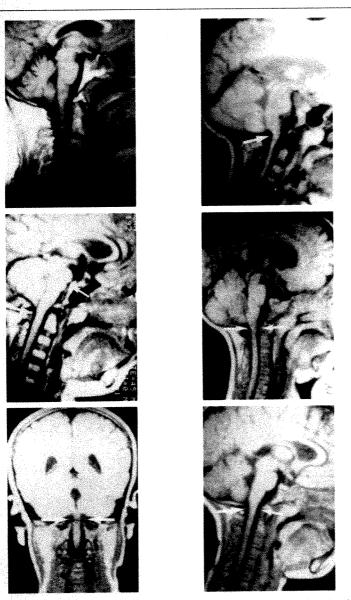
Magnetic resonance imaging appearance in patients with achondroplasia. Top left, Normal. Top right, Posterior compression of medulla. Center left, Anterior indentation of pons, some compression at craniocervical junction. Center right, Posterior indentation of medulla. Bottom left, Bilateral compression of medulla. Bottom right, Tight foramen magnum.
